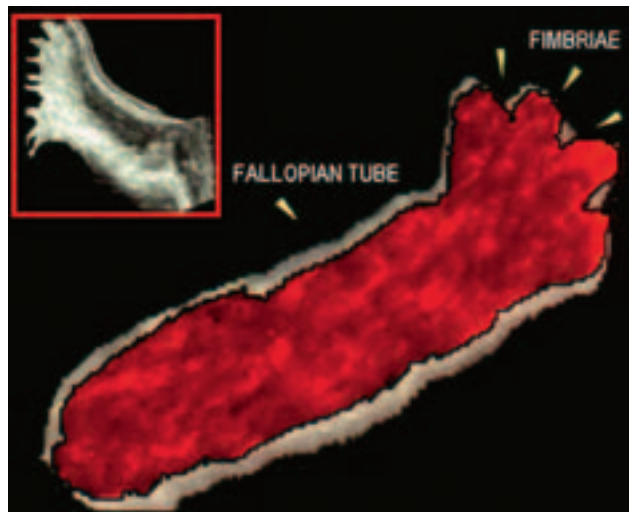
3D power Doppler image showing fallopian tube. Power Doppler shows movement of the fluid going through the Fallopian tube confirming that it is possible to pass through it.
